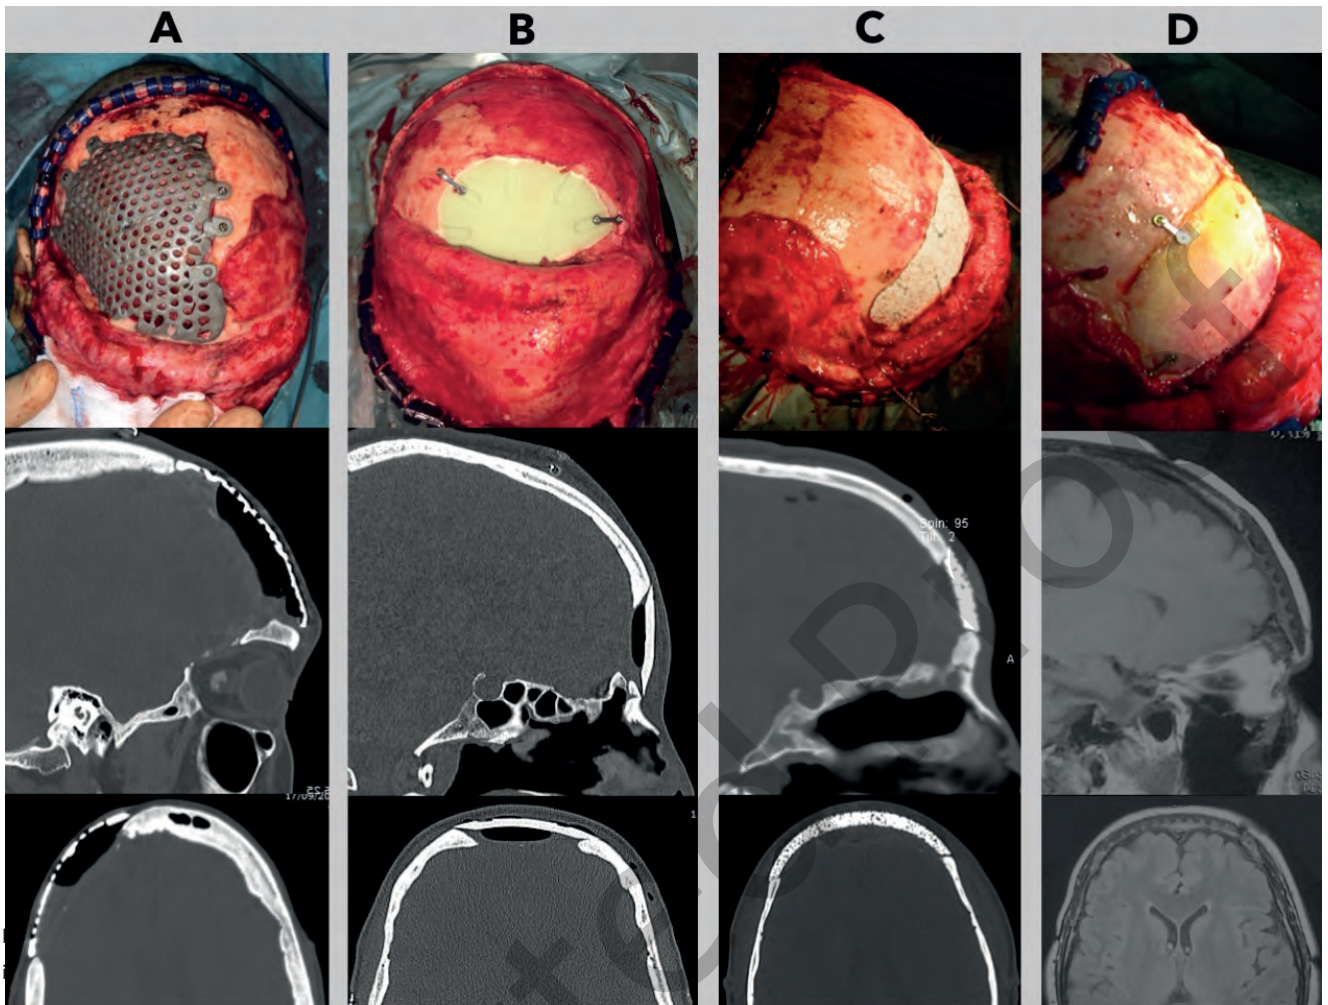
Intraoperative view of the different types of implants after fitting and stabilization: titanium (A), PMMA (B), ceramic (C) and Medpor (D). Radiologic controls show excellent outcomes both on first post-operative day (A and B, CT scan) and one year after surgery (C, CT scan; D, MRI T1 weighted scan).
